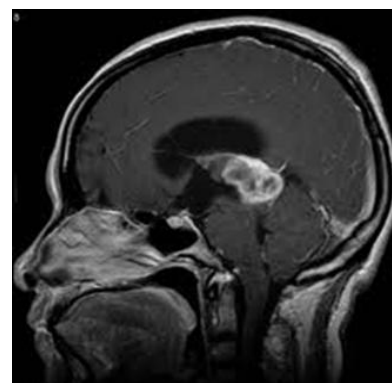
MRI image teratoma in the pineal region
